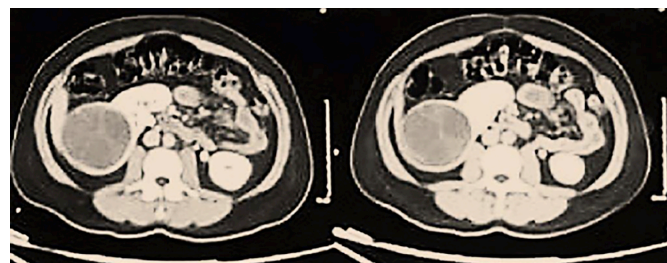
CT abdomen with contrast. Axial images showing upper pole complex renal cyst with internal septations.
